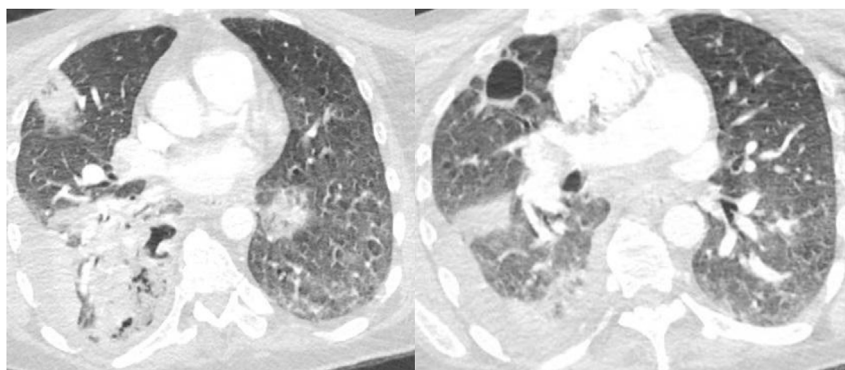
Repeat Computed Tomography of the chest showing right lower lobe consolidation with small right pleural effusion, right upper lobe consolidation with partial ground glass opacity and a right upper lobe cavitary lesion measuring 3.5 × 2 cm.
